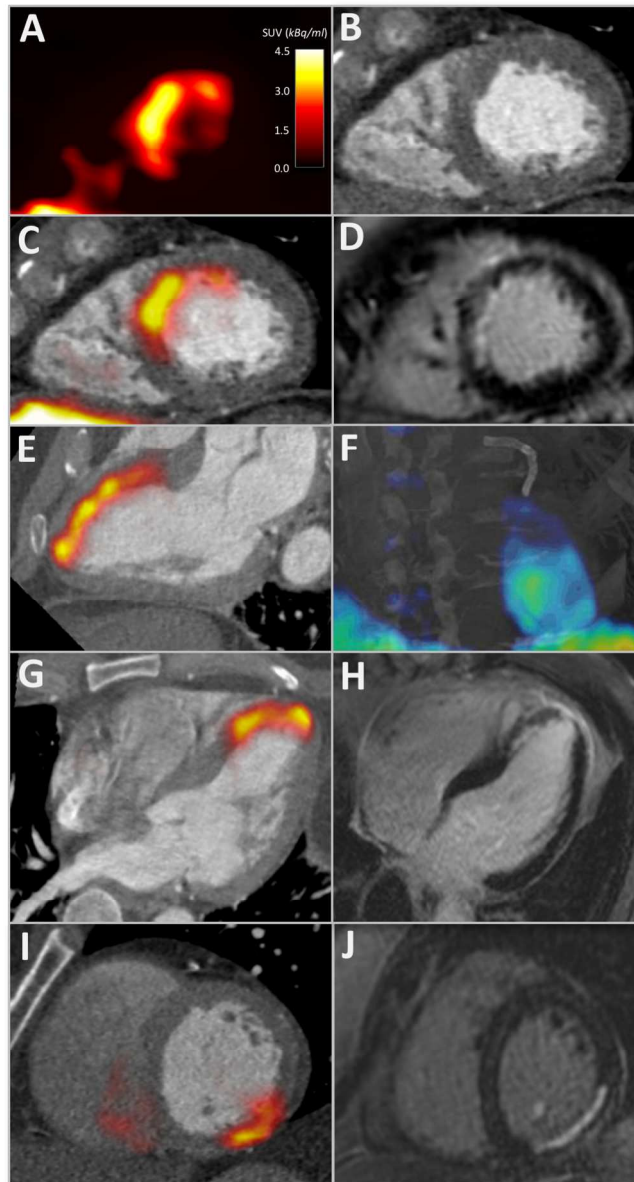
18F-Fluciclatide Uptake in Acute Myocardial Infarction. 18F-Fluciclatide uptake in 3 patients with recent subendocardial myocardial infarction (MI). Patient 1, 13 days after anterior MI, displaying a short-axis PET image of the left ventricle with crescentric 18F-fluciclatide uptake (A) that correlates with the interventricular septum and anterior wall on CT angiography (B). The fused PET/CT-angiography image (C) shows this uptake corresponds exactly to the region of late gadolinium enhancement (LGE) on CMR (D). Further delineation of myocardial uptake on PET/CT is clearer in the 2-chamber view (E) and on a fused CT/3D-Patlak image, which shows this uptake to follow a watershed-pattern emerging from the coronary stents present in the left anterior descending coronary artery (F) (see Video File 1). Panels G & H: patient 2, 8 days following anterior MI, displaying focal uptake of 18F-fluciclatide in the anterior wall and apex in the 3-chamber view on PET/CT (G) which corresponds to the region of infarction on LGE CMR imaging (H). Panels I & J: patient 3, showing focal uptake of 18F-fluciclatide in the inferior wall 19 days following MI on PET/CT (I) that again corresponds to the infarction on CMR LGE imaging (J).
